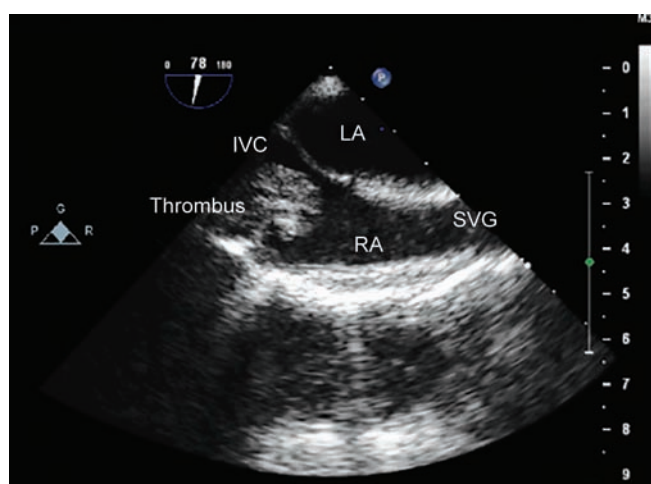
Transesophageal echocardiography visualization of intraatrial tumor thrombus in bicaval view
